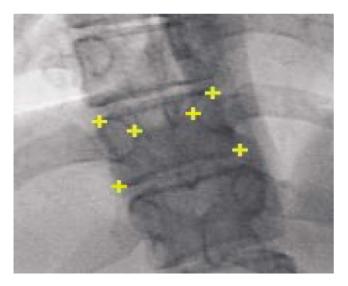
Positions of the digitised landmarks on the corners of the vertebral bodies and the inner edges of both pedicles on the AP radiograph.
